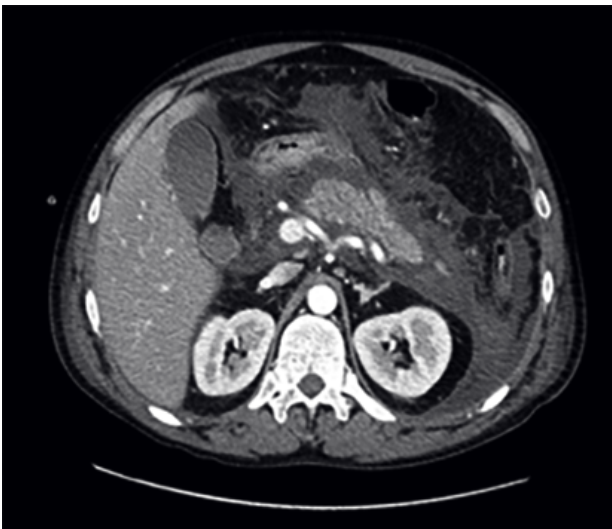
41-years-old man: severe acute pancreatitis CT-scan image. Acute necrotizing process involves the pancreas with extensive alteration of pancreatic structure. There is a wide low density structure of the body and the head. Pancreatic lodge infarction involves celiac vascular structures and lead to initial dislocation of the duodenal C.
